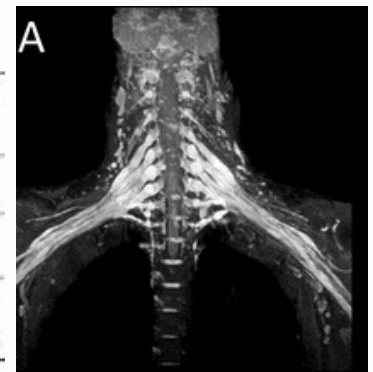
³ The above image is of an MRI in a patient with CIDP which affected their brachial plexuses bilaterally, demonstrating nerve enlargement.
